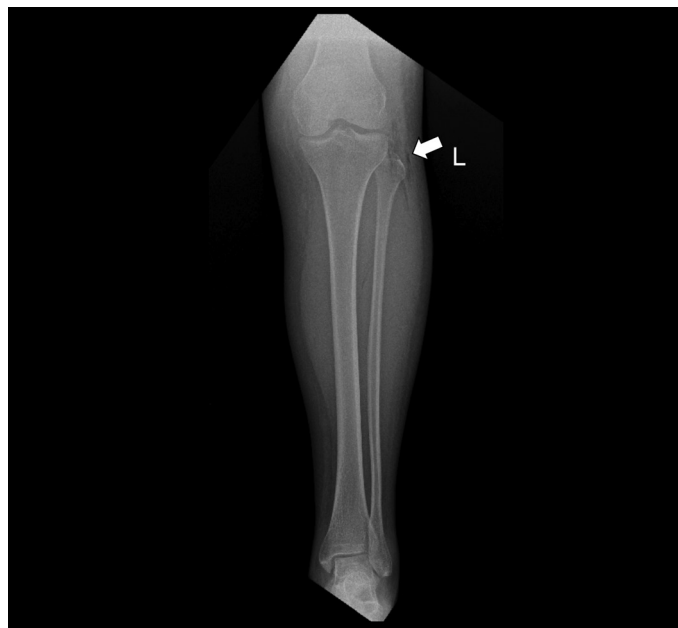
Left knee X-ray. Subcutaneous air densities in the superposed area over the soft tissues and fibula, adjacent to the lateral side of the knee joint
